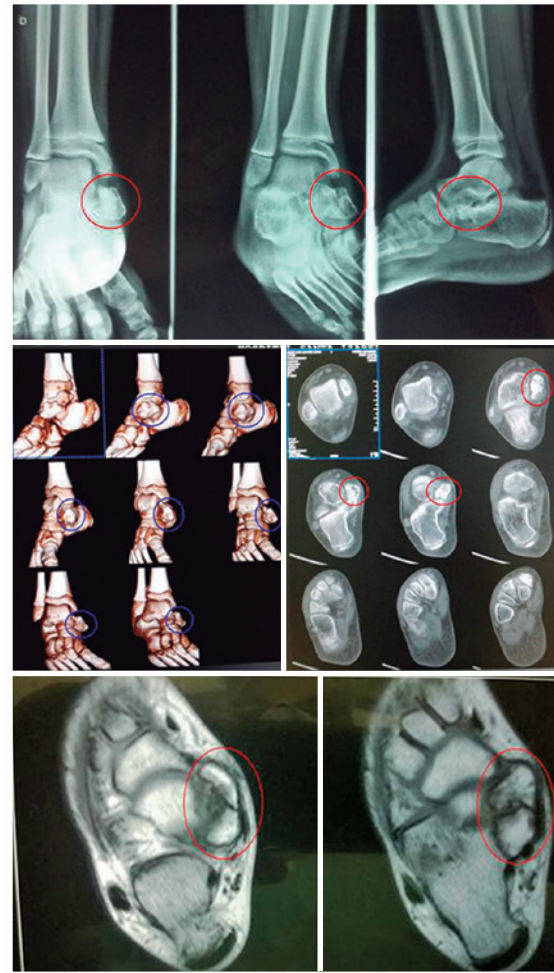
Radiography, computed tomography and nuclear magnetic resonance.
